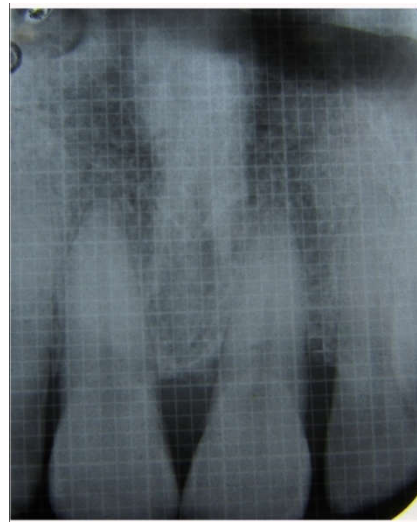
(f). X-Ray with Grid showing intra-bony defect between 21 & 22 at 3 months interval
